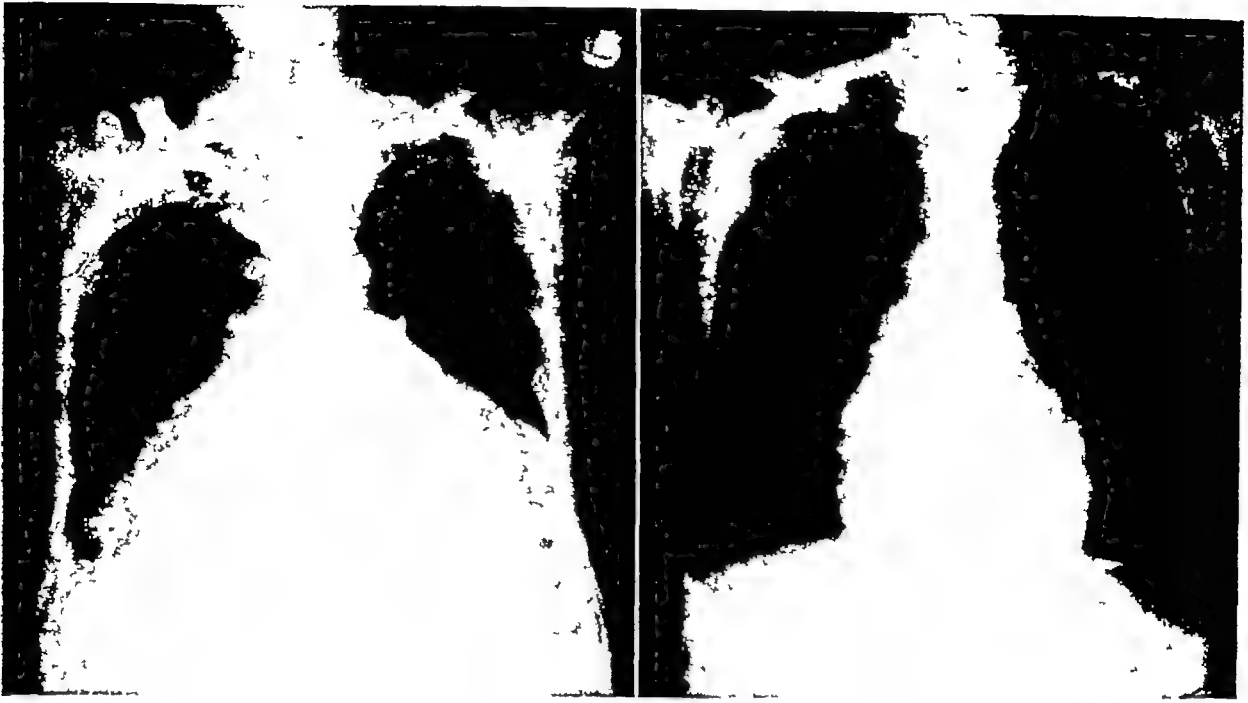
(Left) A diffuse pulmonary metastasis from a liposarcoma primary in the right arm. (Right) Roentgenogram of the chest following a course of deep x-ray, with an excellent response
